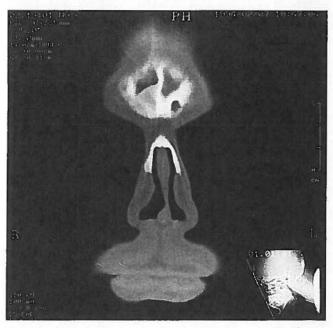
Coronal CT-scan showing fluid level in the right frontal sinus.
